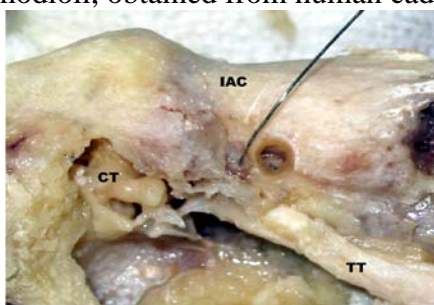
The probe shows ganglion geniculi. Greater petrosal nerve is resected. Medially and anteriorly to ganglion geniculi is seen the cochleostomy. IAC – internal auditory canal; CT – cavum tympani; TT – m. tensor tympani.
